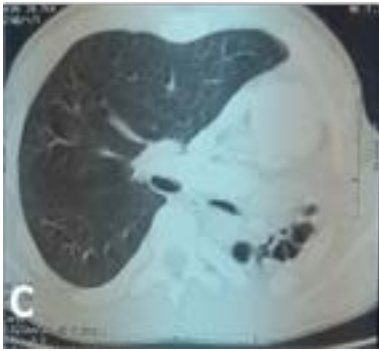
C: Axial (C) and frontal (D) CT scan cuts showing the development of multiple air filled cavities within the lung parenchyma
